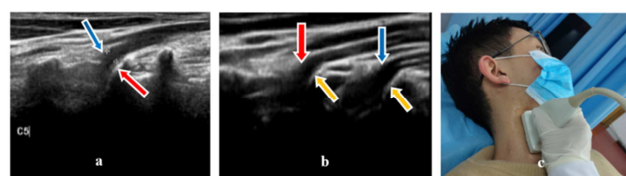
The ultrasonographic characteristics of nerve in long axial section.
